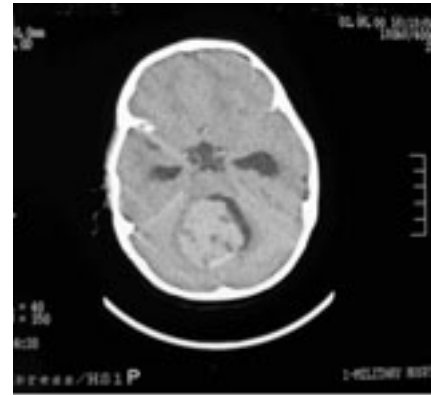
A CT scan of a medulloblastoma in a 2-year-old child presenting with vertigo.
